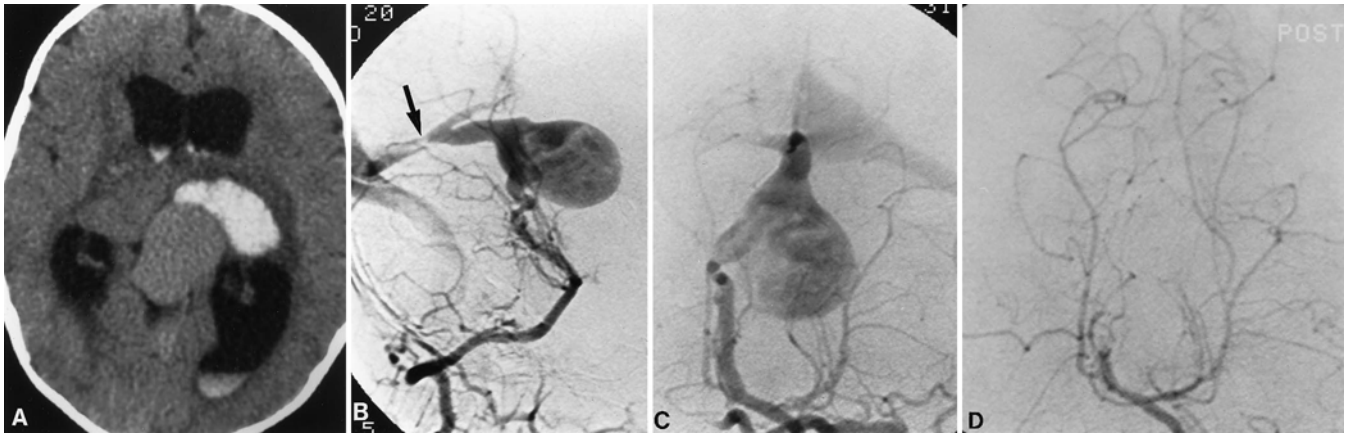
Case 3. A: Unenhanced CT scan demonstrating acute hemorrhage in the right thalamus and internal capsule with IVH. B and C: Left vertebral injection arteriograms, lateral (B) and anteroposterior (C) projections, demonstrating a mural-type VGM supplied by a single enlarged lateral posterior choroidal artery. A high-grade stenosis is present in the draining falcine sinus (*straight arrow*). D: Left vertebral arteriogram, Towne's projection, obtained after embolization with silk suture, demonstrating complete obliteration of the fistula site. Complete and persistent closure of the VGM was confirmed on a 12-month follow-up arteriogram.
